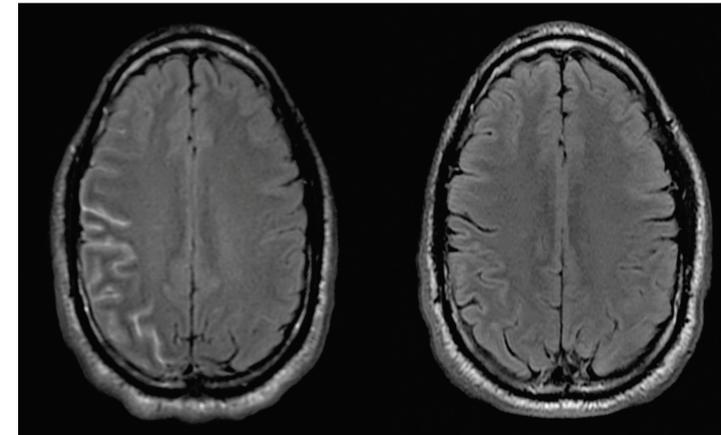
Initial brain MRI (left), axial T2 FLAIR, with hyperintensity evident in the region of the right parietal lobe. Two months post-treatment, the patient's brain MRI (right) demonstrated resolution of corresponding hyperintensity.
